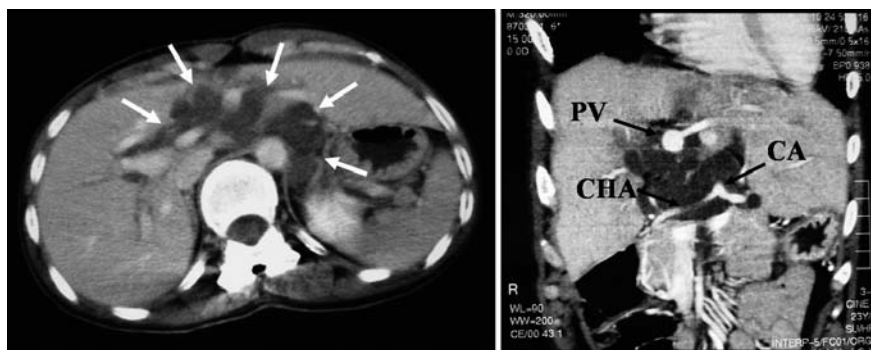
Contrast-enhanced computed tomography showing a low-attenuation lesion involving the celiac axis (CA), the common hepatic artery (CHA), and the portal vein (PV), and extending into the hepatic hilum (arrows).
